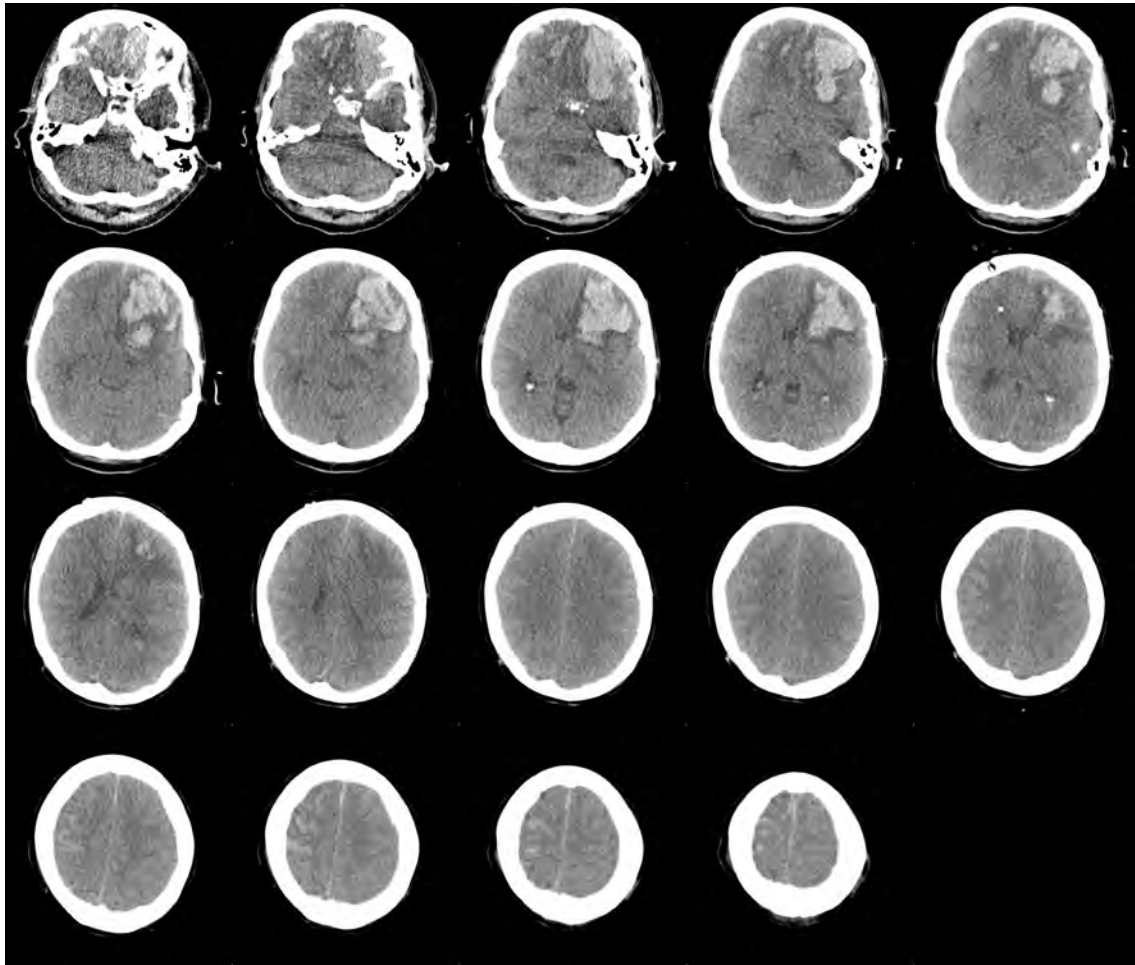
Montage of the non-contrast CT head showing large left frontal contusion and smaller right frontal contusions
